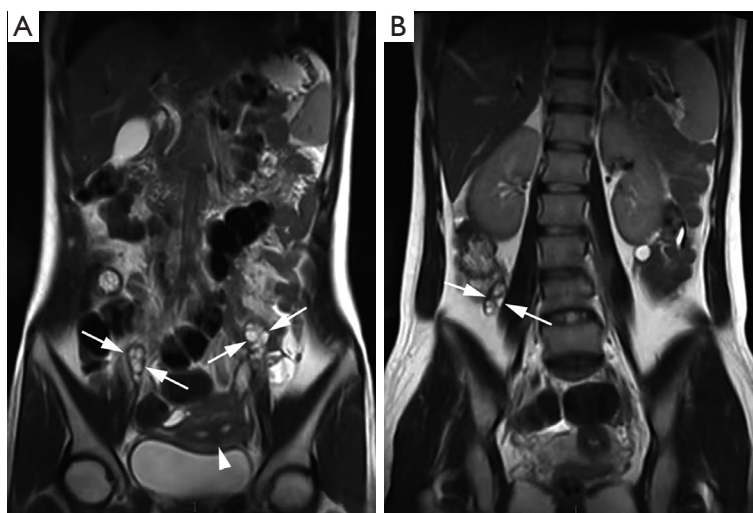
Postoperative total abdominal and pelvic MR imaging. (A,B) Coronal T2-weighted MR images revealed a septate uterus (A, arrowhead), 2 normally placed ovaries (A, arrows), and a supernumerary ovary (B, arrows) near the right psoas major. MR, magnetic resonance.
